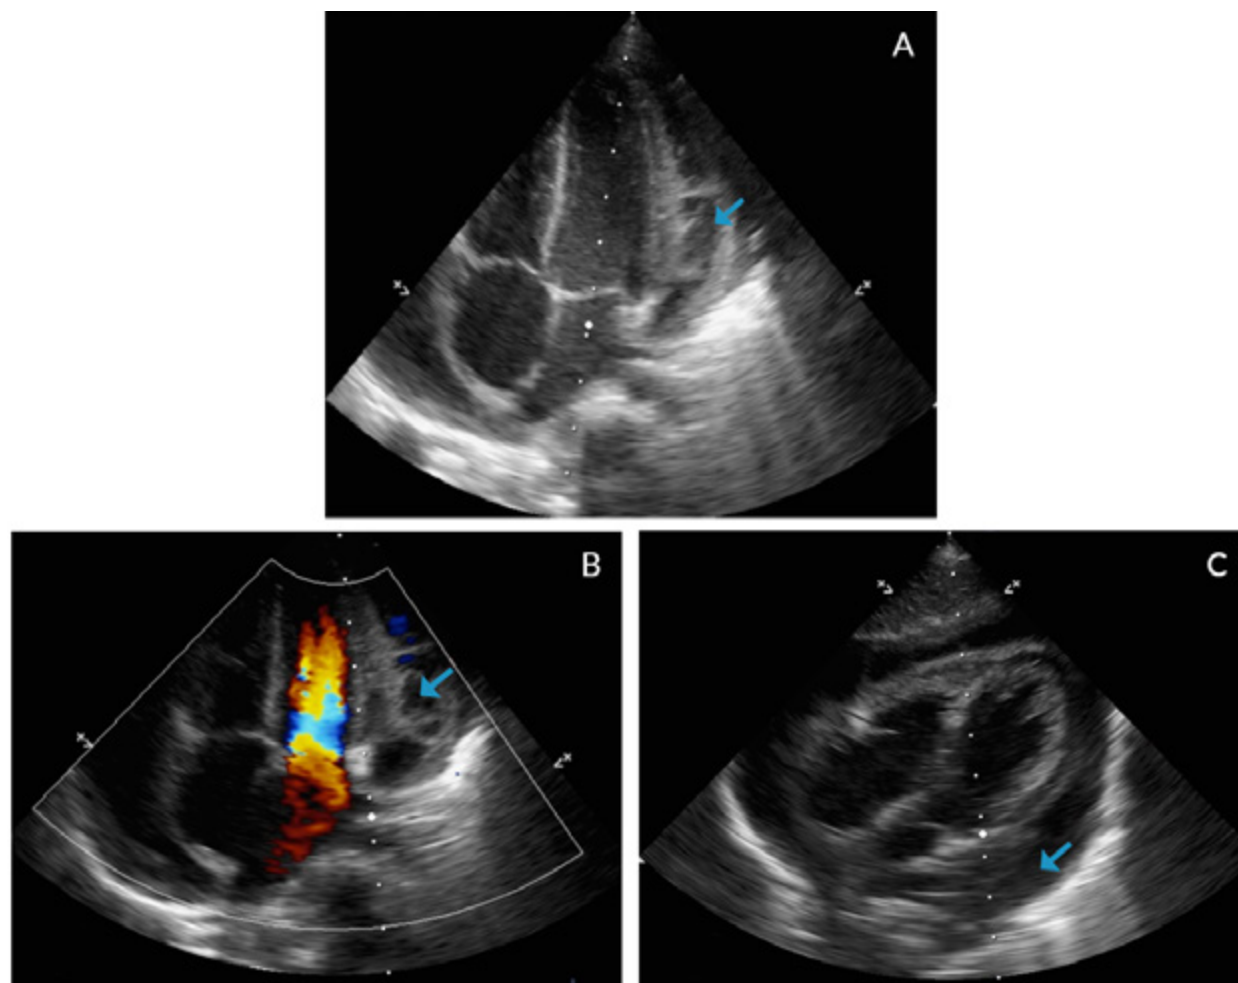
Echocardiogram with apical four chamber view (A, B) and coronal axial plane (C).
